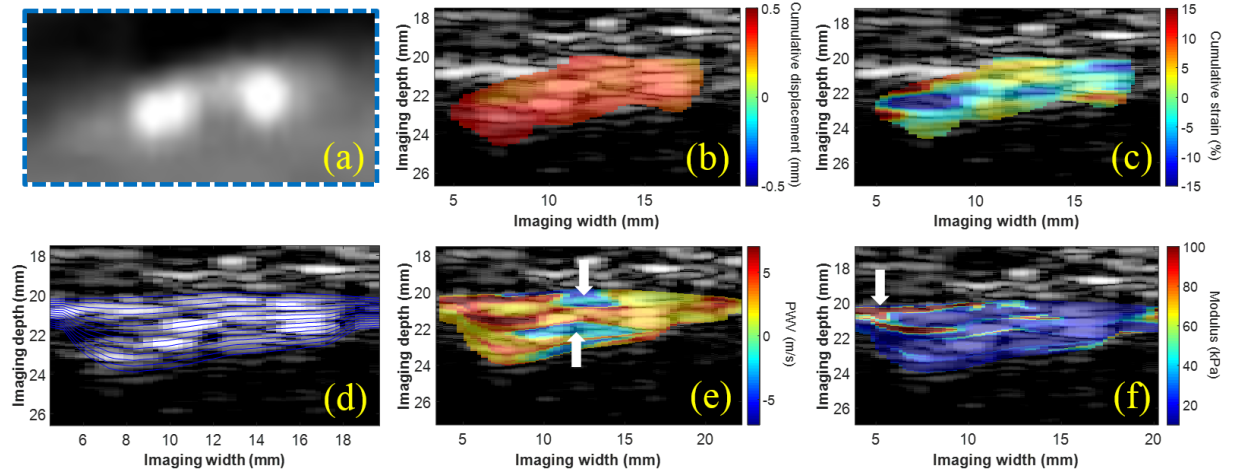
(a) Enlarged view of plaque #1 from the CTA in Figure 6.9a. The intra-plaque cumulative displacements (b) appeared uniformly distributed within the plaque ROI, while regions of tissue compression (blue) and elongation (red) were observed on the cumulative strain map. (d) Multiple wall traces were generated for intra-plaque PWV and modulus mapping. The PWV map (e) shows regions of negative PWV (white arrows) in between regions of positive PWV that appear to correlate with the two calcified inclusions observed on the enlarged CTA image (a). The modulus map (f) appeared mostly uniform with a small region of increased modulus immediately before the plaque (white arrow).
